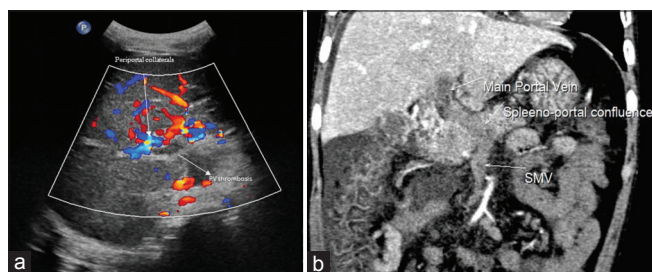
(a) Doppler image showing portal vein thrombosis with periportal collaterals and (b) computed tomography angiography showing noncontrast filling of main portal vein extending up to the splenoportal confluence and into the superior mesenteric vein
